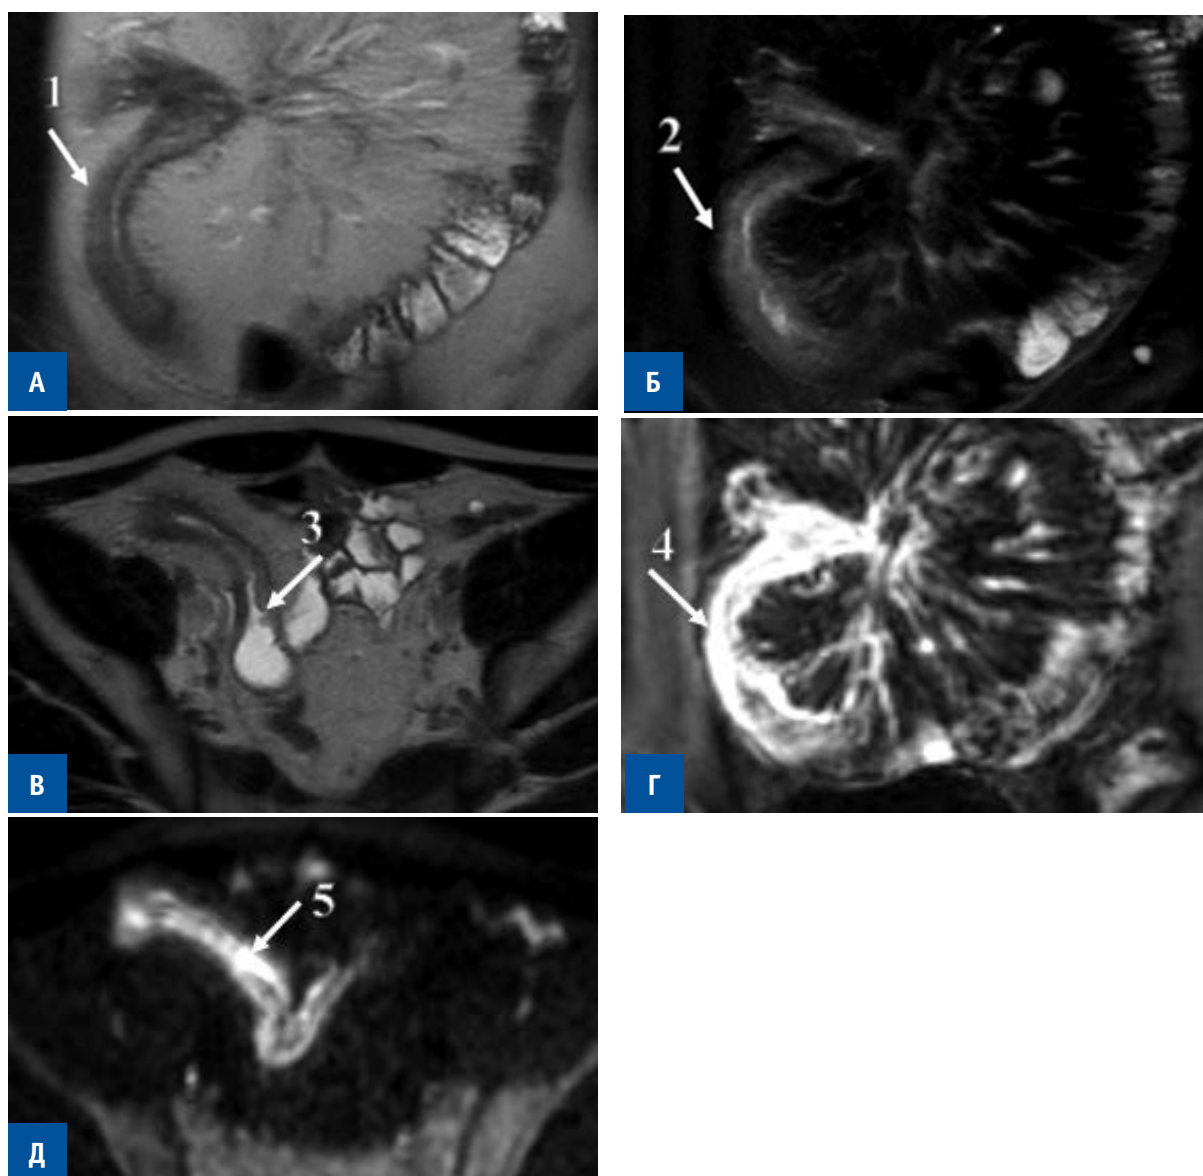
MRI. Crohn's disease in the form of ileitis. A — T2-weighted image, cor; Б — T2-weighted image with fat suppression, cor; B — T2-weighted image, ax; Г — T1-weighted image with contrast enhancement, cor; Д — diffusion-weighted image, ax. 1 — thickening of the intestinal wall, 2 — edema of the submucosal layer, 3 — ulcerative defect, 4 — transmural accumulation of a contrast agent, 5 — restriction of diffusion from the intestinal wall.
